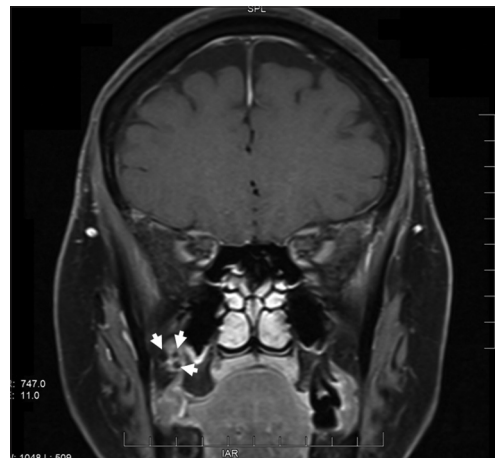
Contrast enhanced T1W coronal magnetic resonance imaging showing the phleboliths within the hemangioma on the right side in the pterygomaxillary fissure
